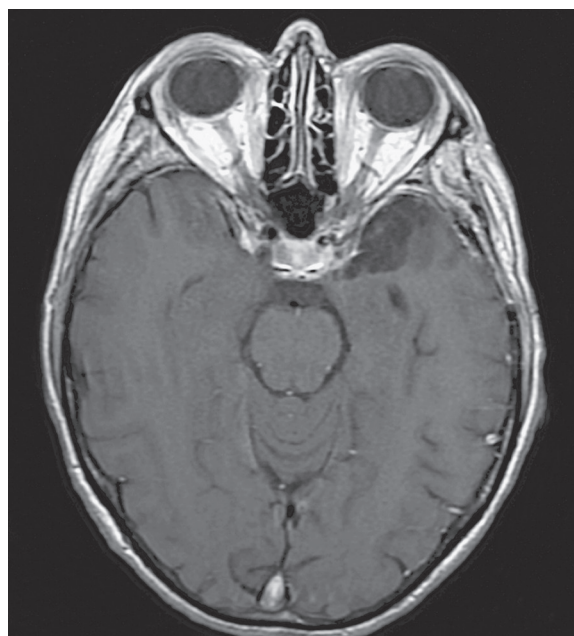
Postoperative MRI 4 months after surgery: T1-weighted sequence after gadolinium injection, showing complete resection of the meningioma.
